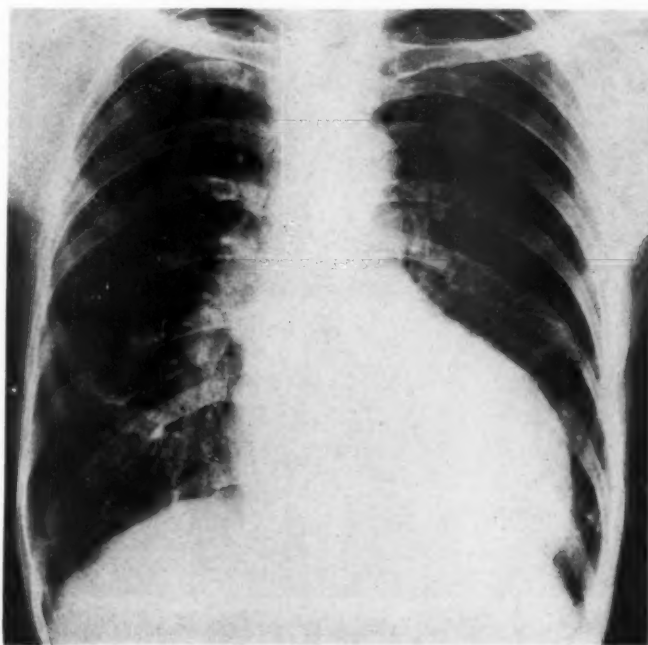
(Case 2).—The roentgenogram of the chest shows marked cardiac enlargement with preponderance of the left ventricular component.
